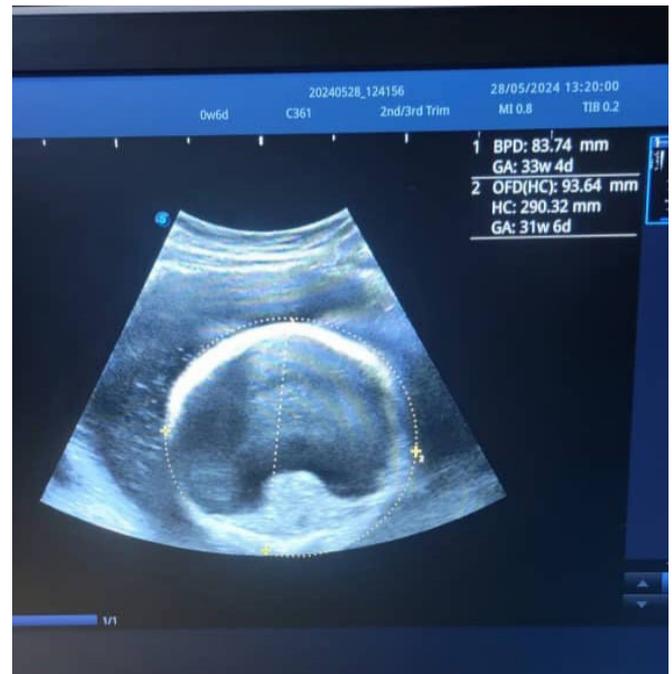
Ultrasound scan showing a heart-shaped thalamus fused in the midline, absent falx with a single large ventricle.
